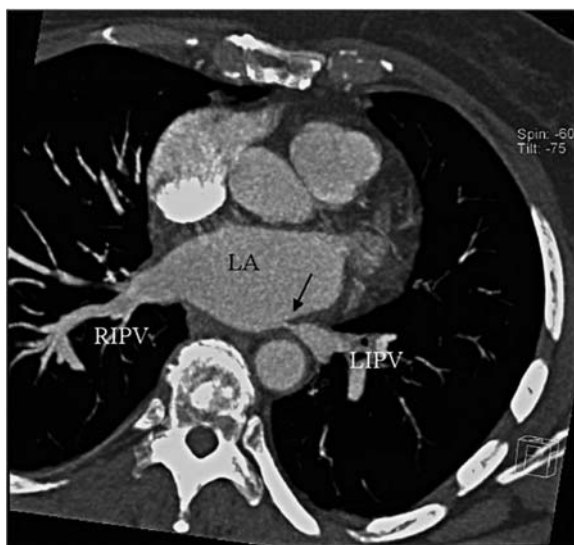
Spiral CT scan at the level of the inferior PVs demonstrating a severe narrowing (arrow) of the proximal portion of the left inferior PV (LIPV). This location probably indicates that radiofrequency (RF) lesions were in fact placed inside the vein. RIPV Right inferior PV, LA left atrium
